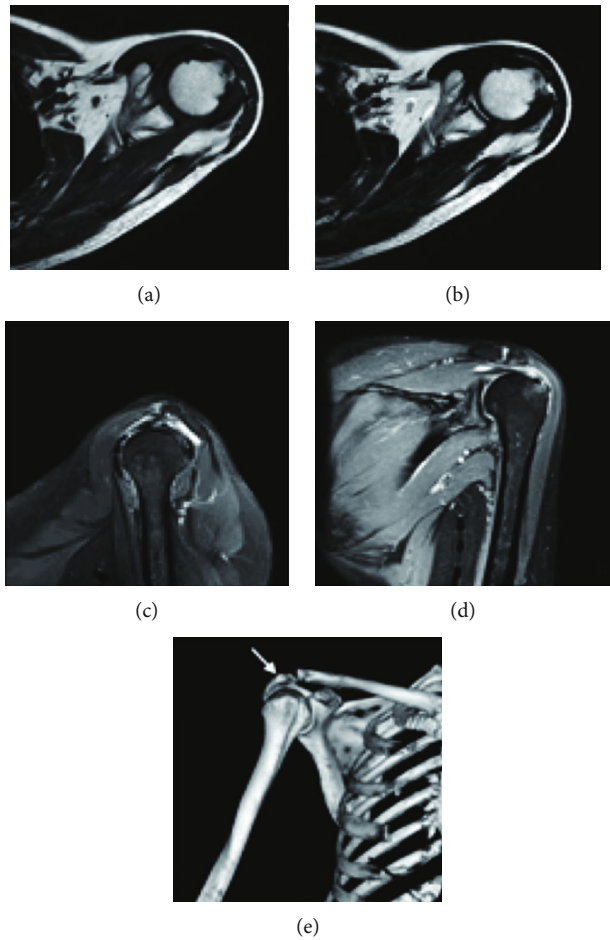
MRI and CT images of patients with SIS. T1WI (a) and T2WI (b) examined by MRI, which indicated the swelling condition of the supraspinatus tendon and uneven signal; oblique (c) and coronal (d) positions detected by MRI—partial tear of the supraspinatus tendon is shown in (c) and subacromial bursitis is seen in (d); (e) the CT three-dimensional reconstruction image of hook grade acromion, and hyperosteoecy occurred in the acromion margin.
